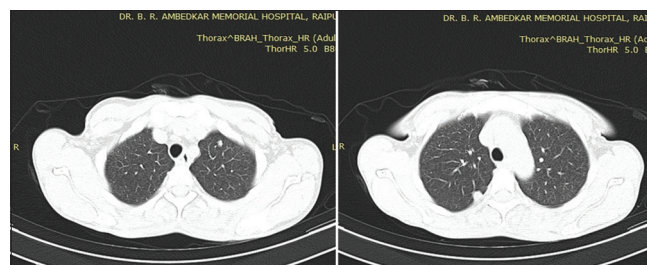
Axial HRCT images through the upper lobes showing subpleural nodules in a case of cryptococcosis
